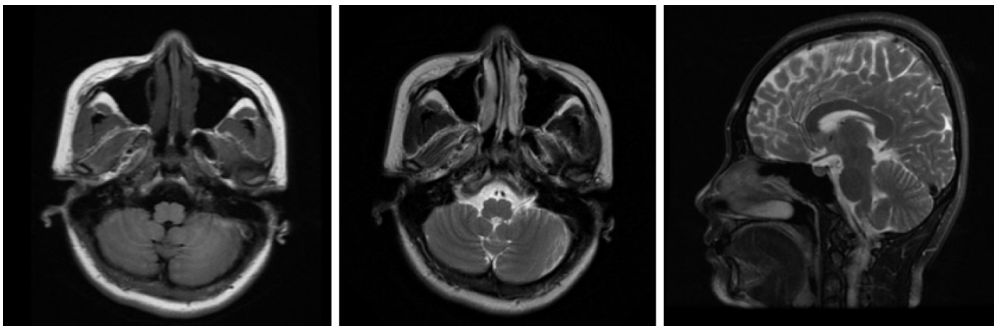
Brain magnetic resonance imaging. The image on the left is the T1-weighted axial image, the image in the middle is the T2-weighted axial image, and the image on the right is the T2-weighted sagittal image. No cerebellar atrophy was observed.
